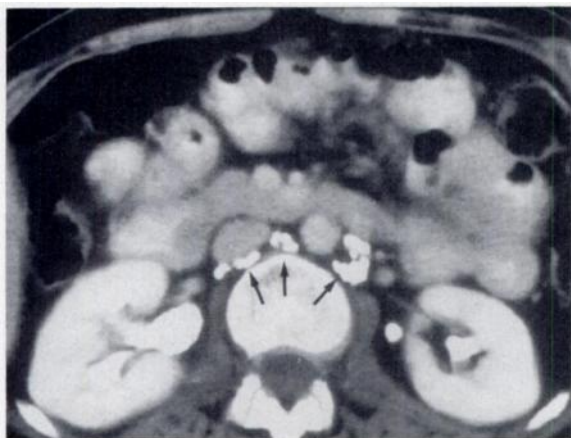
CT scan obtained subsequent to lymphangiography shows multiple, opacified, normal-sized retroperitoneal nodes (arrows).
